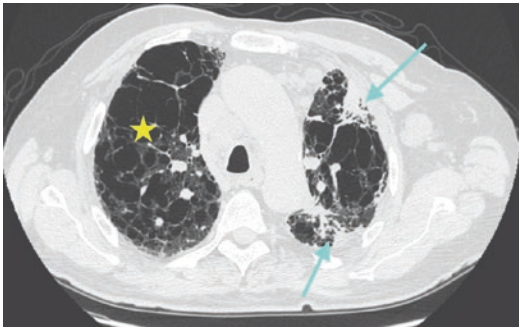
Medical history: A 70-year-old man who worked for 30 years in a shipyard. Axial image from a thin-section unenhanced CT scan (1.0-mm-thick sections) in lung window settings shows subpleural consolidation (arrow) referred to as mesothelioma in the upper left lobe, with reticulation, honeycombing, and advanced pattern of emphysema (yellow star)
